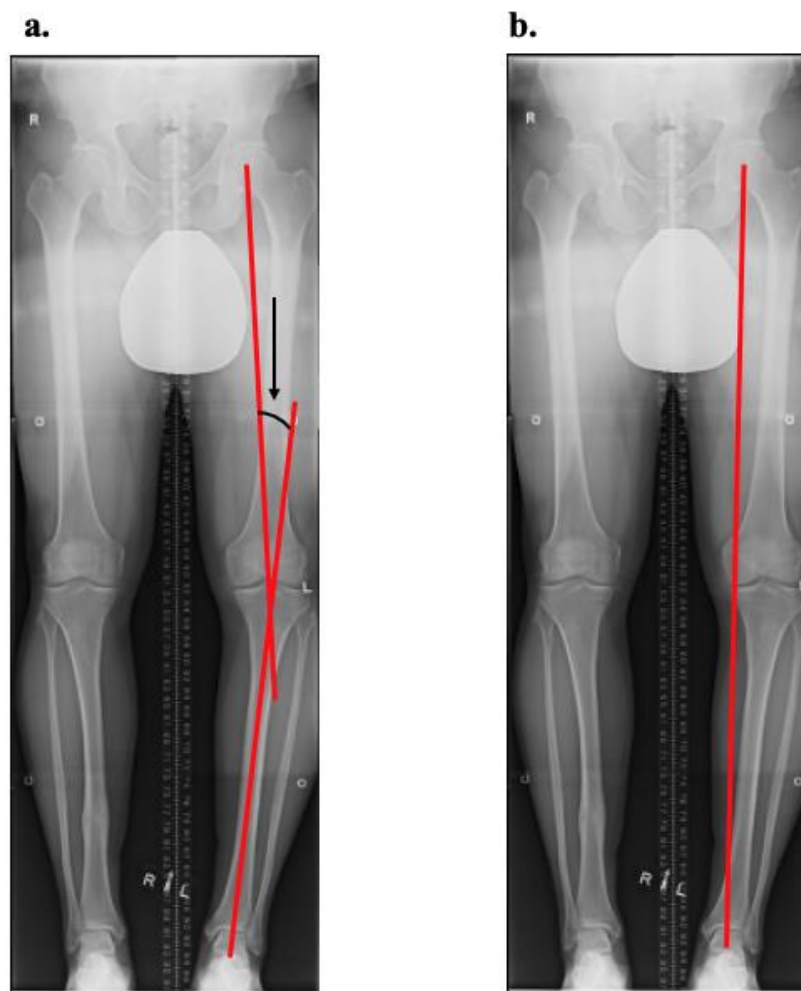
a. Antero-posterior hip-to-ankle standing radiograph showing the mechanical axis angle (MAA). The MAA is measured as the angle created by a line drawn from the centre of the femoral head, through the center of the knee joint (between the tibial spines), and a separate line drawn from the centre of the knee joint extending through to the centre of the ankle joint. A negative MAA indicates varus, while a positive MAA indicates valgus, alignment of the lower limb. The angle observed within this radiograph indicates a varus angle of 9.6° . b. The weightbearing line is the line from the center of the hip joint to the center of the ankle joint.
